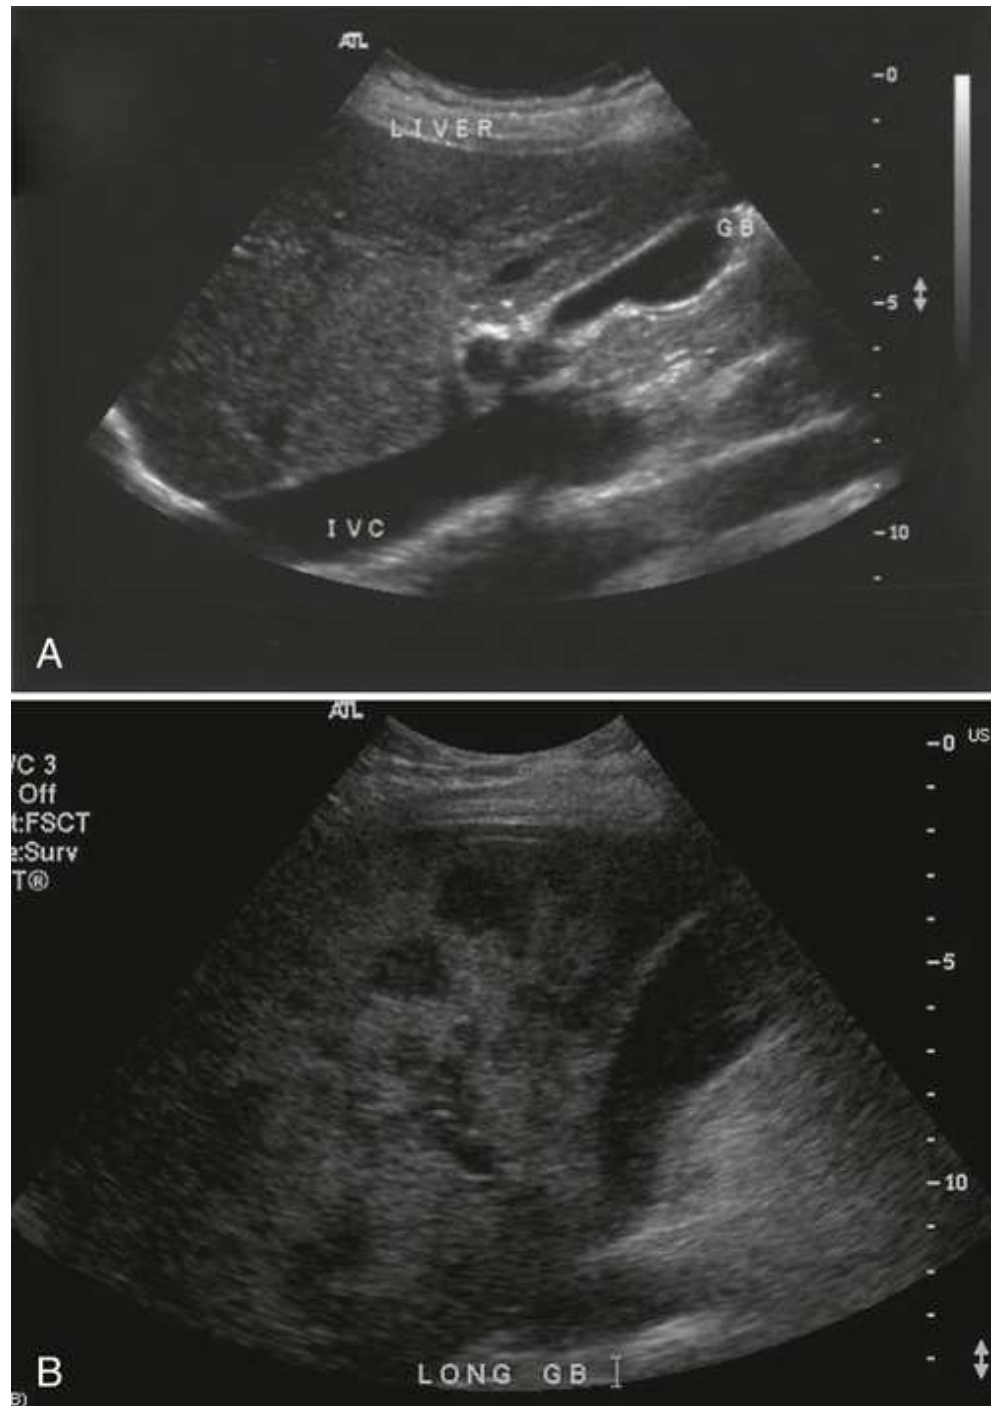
(A) Sagittal sonogram of normal homogeneous liver. (B) Longitudinal sonogram of heterogeneous hepatic lobe in a patient with a history of breast carcinoma.
